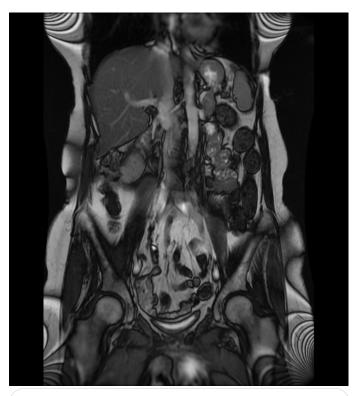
Post-treatment MRI after completion of therapy with Obinutuzumab and Venetoclax. The patient has had complete resolution of disease. MRI was chosen as the imaging modality of choice due to patient concerns of radiation with traditional CT imaging.
